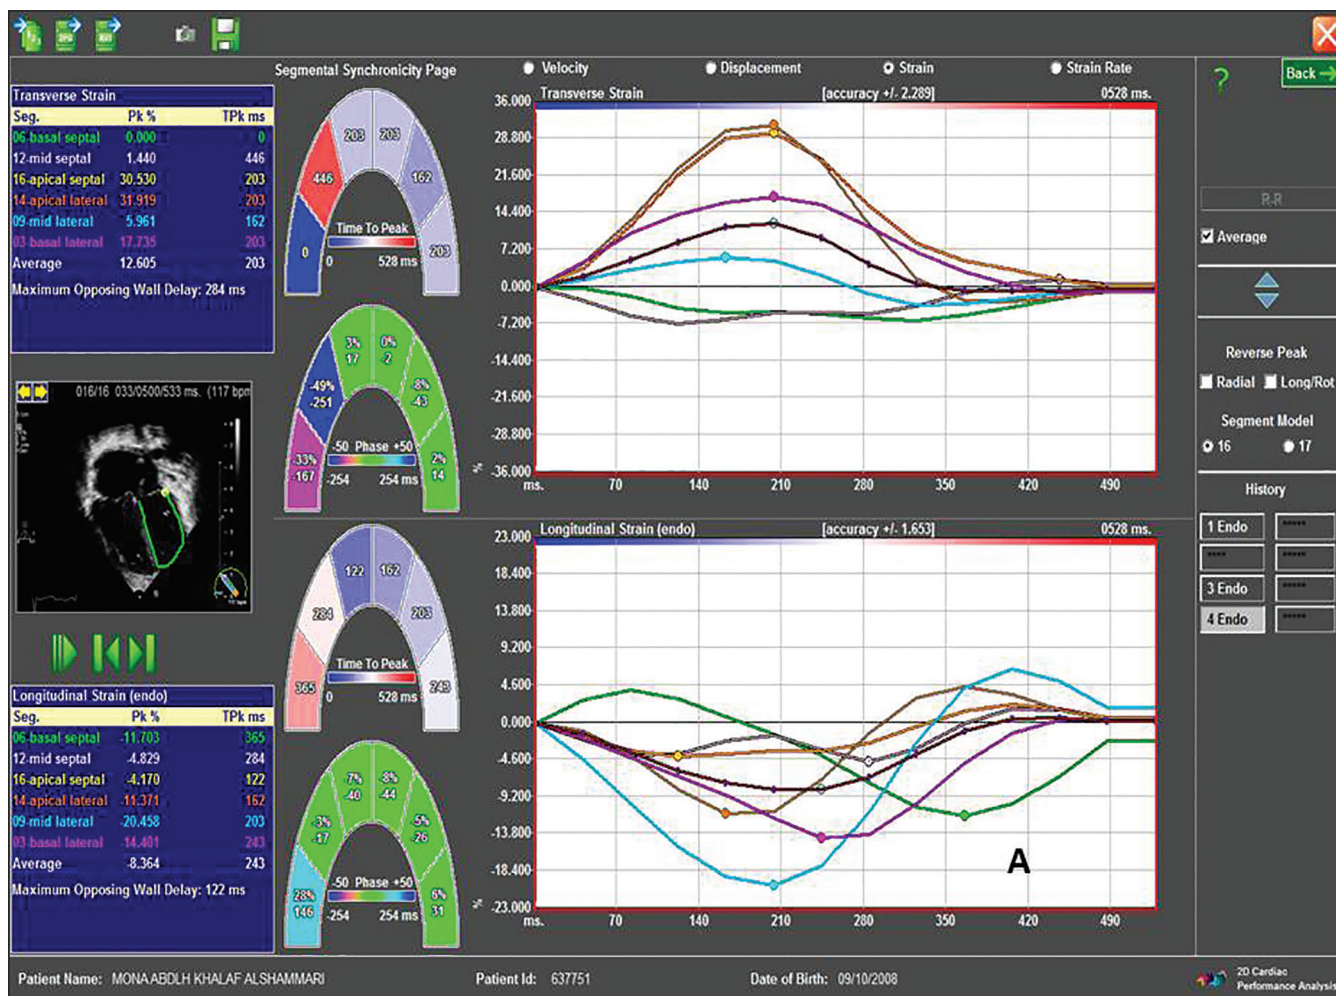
Speckle tracking analysis of the left ventricle (LV) from the apical four chamber view revealing a significant abnormally reduced LV deformation (A)
